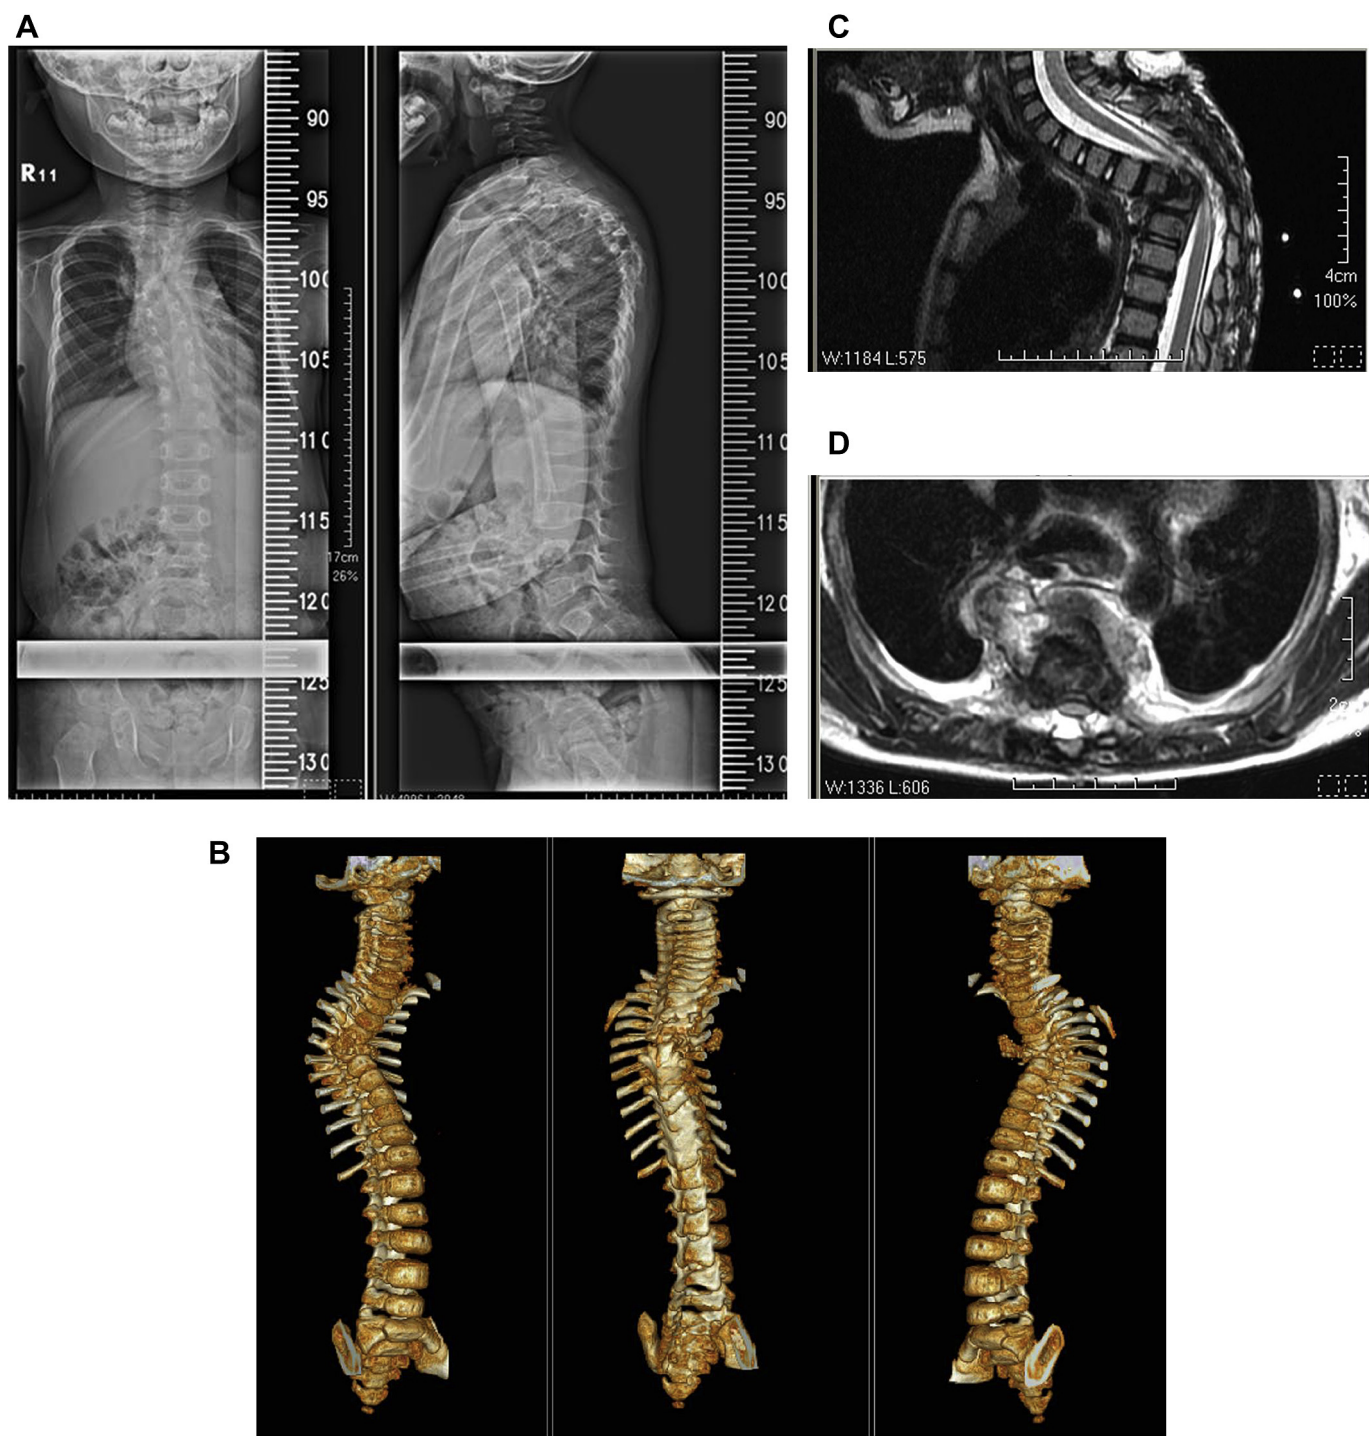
A 2-year-and-10-month-old boy with BCG spine, T4–T6 paraspinous abscess formation and kyphotic deformity. (A) Radiograph, anterior–posterior and lateral views. (B) Spinal 3D computed tomography reconstruction. (C) T-spine magnetic resonance imaging (MRI) T₂-weighted sagittal view. (D) T-spine MRI T₂-weighted coronal view.
